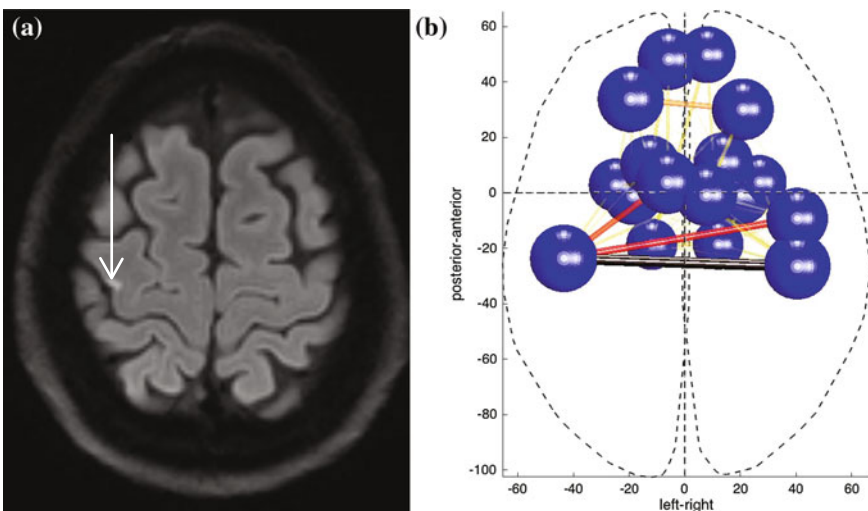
Representation of node and connections strengths in the motor network after stroke. *Legend a* Isolated primary motor cortex (M1) stroke (DWI sequence) ; *b* The size and shade of connections reflects their weight. The size of each sphere is proportional to its regional weight (sum of the weights of all connections between this region and the rest of the network)
